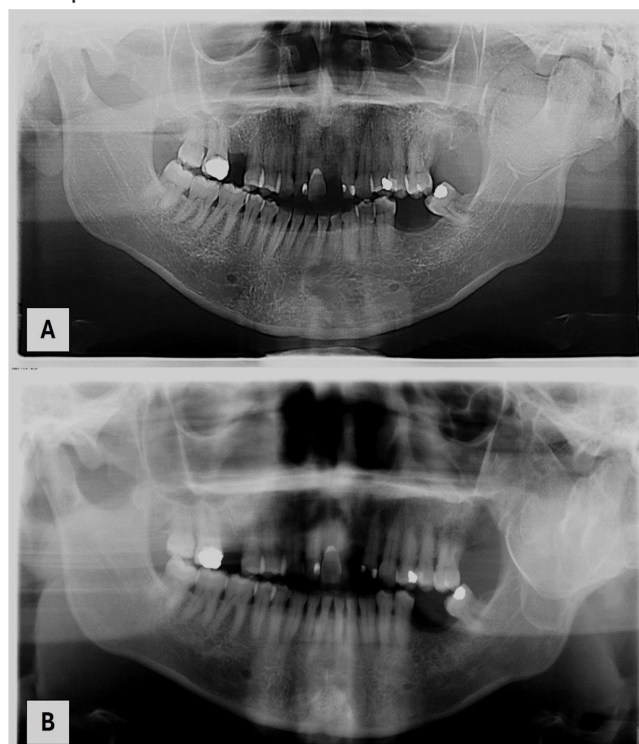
Panoramic radiographs showing the evolution of the lesion over approximately 10 years (A – 2013; B – 2022), with a multilobulated and corticated radiopaque image in the region of the ascending ramus of the mandible and the condyle.
